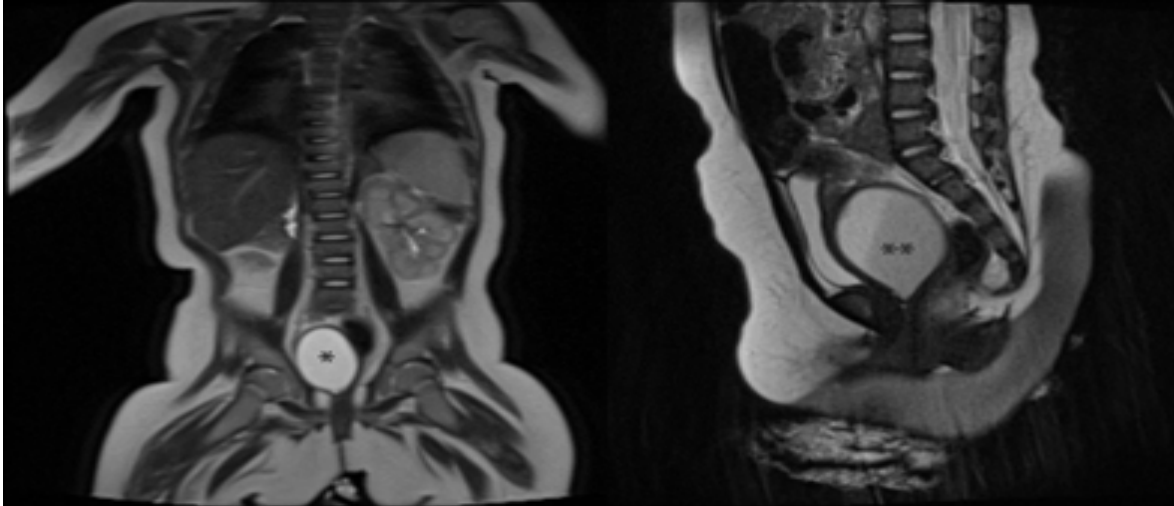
Magnetic resonance images of right-sided hydrometrocolpos (3×2 cm in size) in a five-month-old patient prenatally diagnosed with right renal agenesis. (Black asterisk: right hydrometrocolpos in the coronal plane; double black asterisk: hydrometrocolpos in the sagittal plane).
